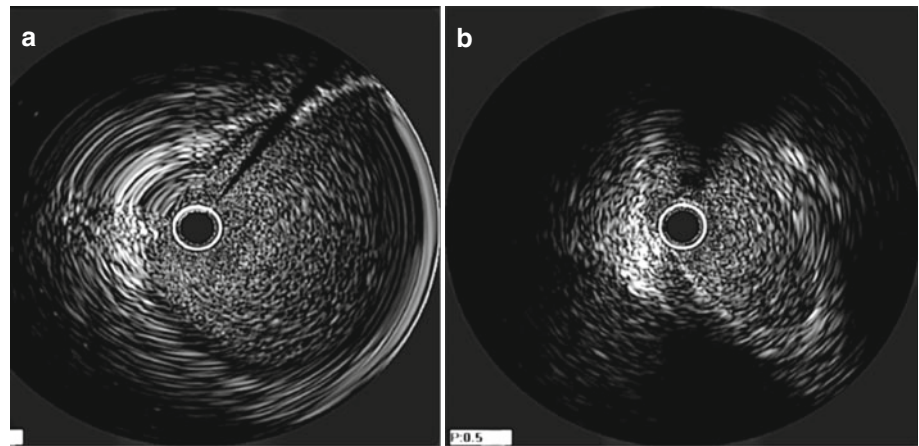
Intravascular ultrasound (IVUS) images in a case of right coronary artery arising from the opposite sinus (R-ACAOS) (see Fig. 13.29) in a patient with atypical chest pain and a negative stress-test result. (a) Distal cross-section; (b) proximal cross-section, close to the ostium. The cross-sectional proximal area (in view b) is fairly well
